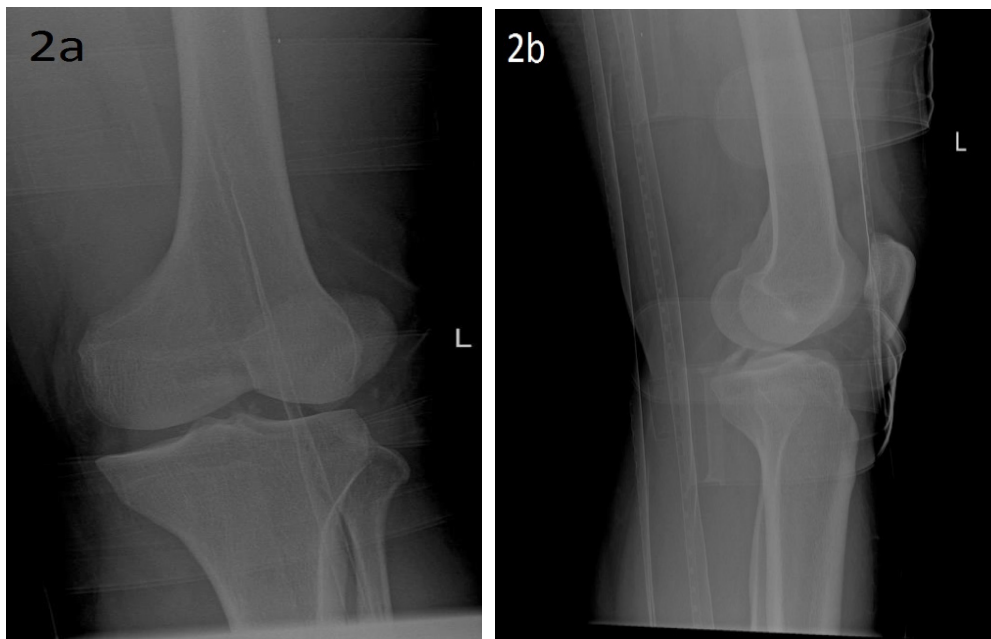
Radiograph AP (2a) and lateral (2b) of left knee showing avulsion fracture of the posterior cruciate ligament
